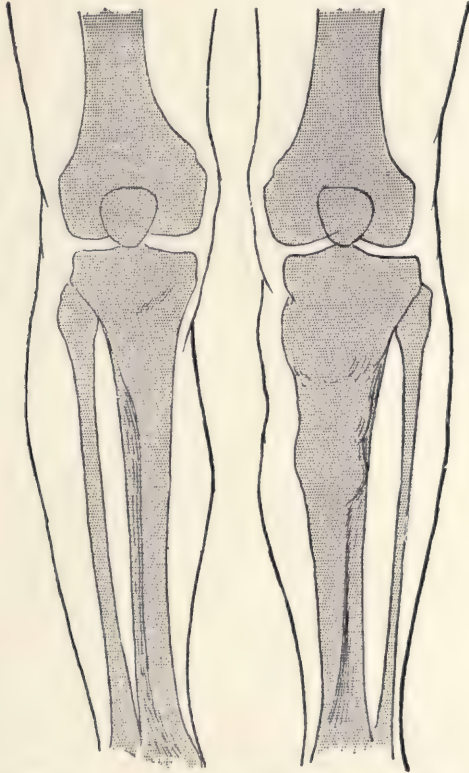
Osteo-myelitis of the left tibia (from a radiograph). The bone is hypertrophied and irregularly bossed; the swelling is not limited so markedly as in osteo-sarcoma. The right tibia is normal.
